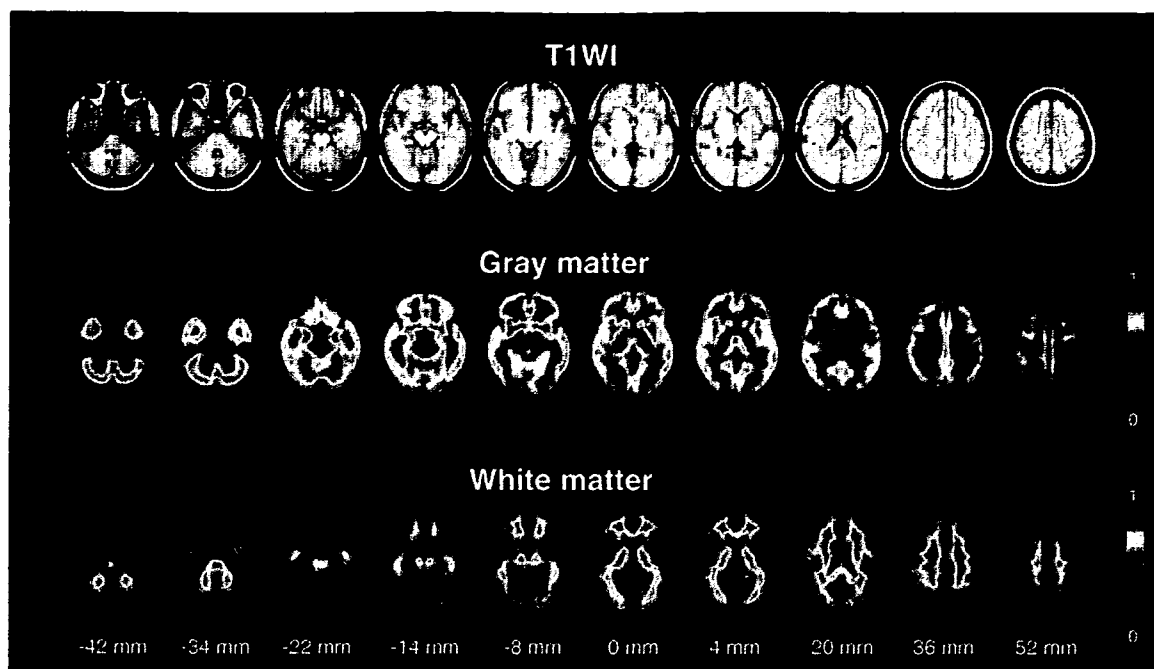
Anatomically standardized averaged T1-weighted MR images and averaged images of gray and white matter fractions. All images are transaxial sections parallel to the AC–PC line. The slice positions are -42 , -34 , -22 , -14 , -8 , 0 , 4 , 20 , 36 , and 52 mm from the AC–PC line. The anterior is at the top of the image and the subjects' right is at the left. Scale maximum and minimum values for gray and white matter images are 1 and 0 of gray and white matter fractions (mL/mL), respectively. T1WI, T1-weighted image.
